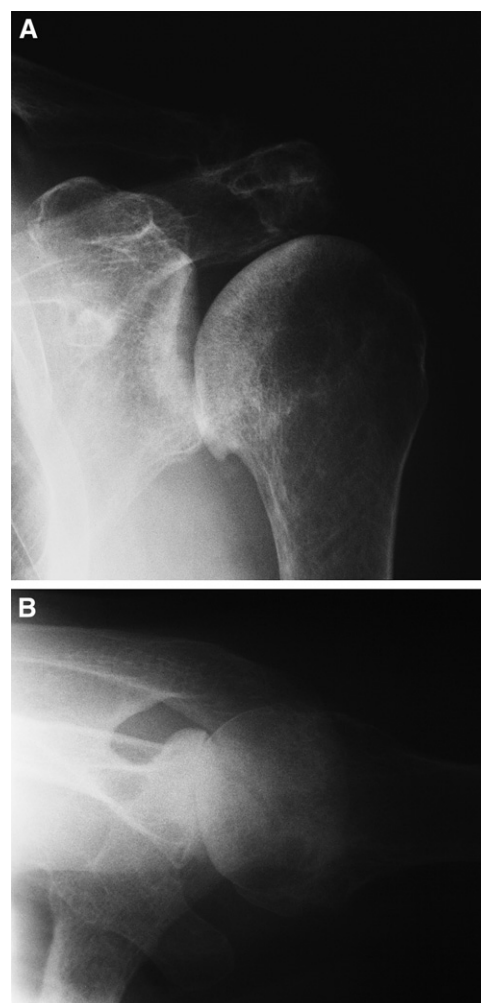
(A) Anterior and (B) axillary lateral radiographic views of the patient's left shoulder show arthritic changes, including loss of the glenohumeral joint space.
